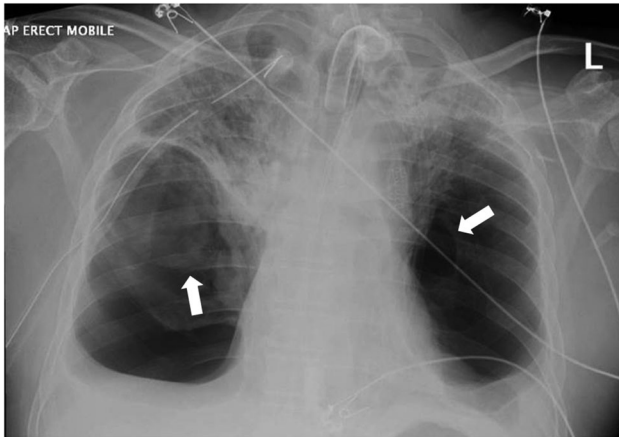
Chest radiograph revealing giant bilateral pulmonary cavitations (indicated by arrows).
